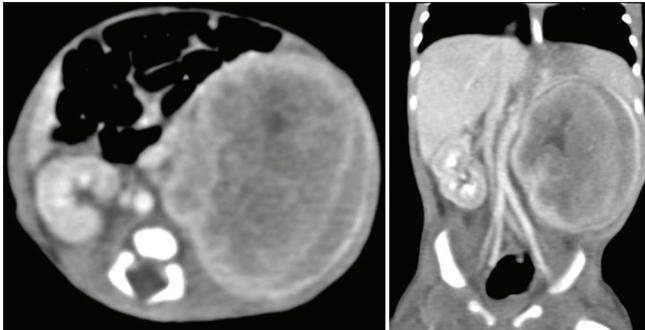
The computed tomography revealed left renal heterogeneous tumor, 5.2 cm × 5.1 cm × 5.8 cm, involving the upper and middle poles showing perirenal fluid collection and enhanced Gerota's fascia
